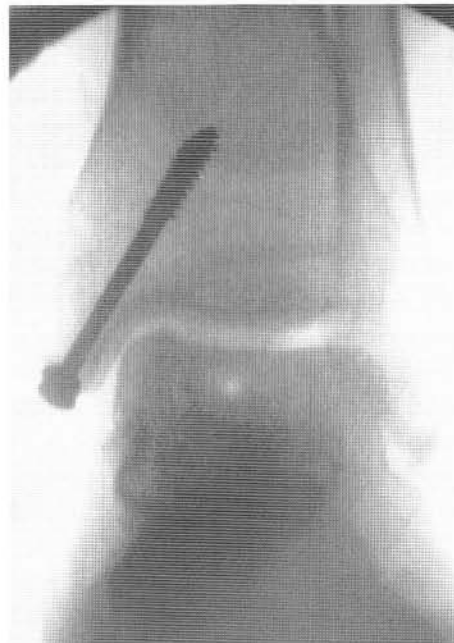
Intraoperative x-ray showing allograft and fixation intact.
